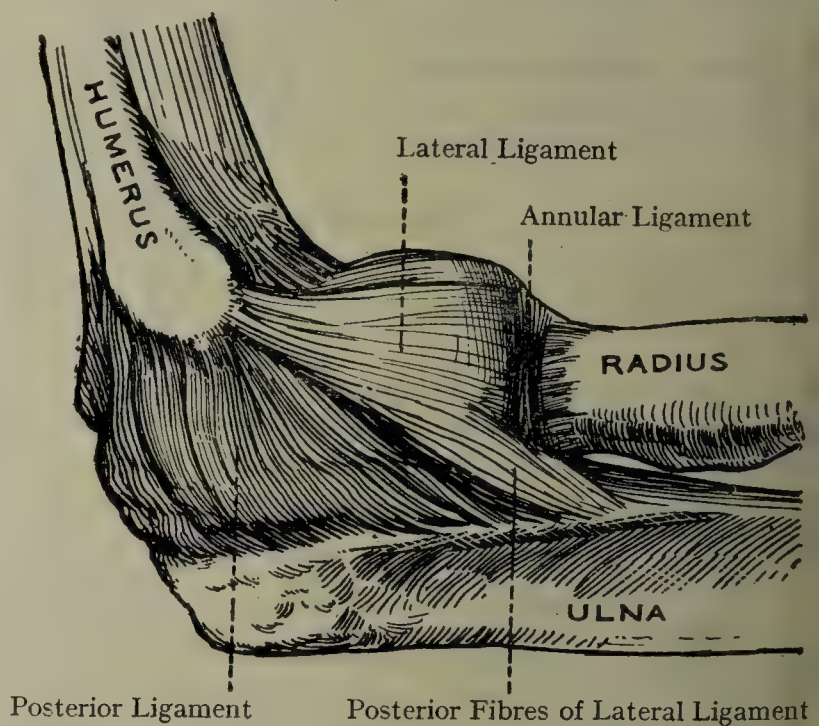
THE RIGHT ELBOW-JOINT (LATERAL ASPECT).
